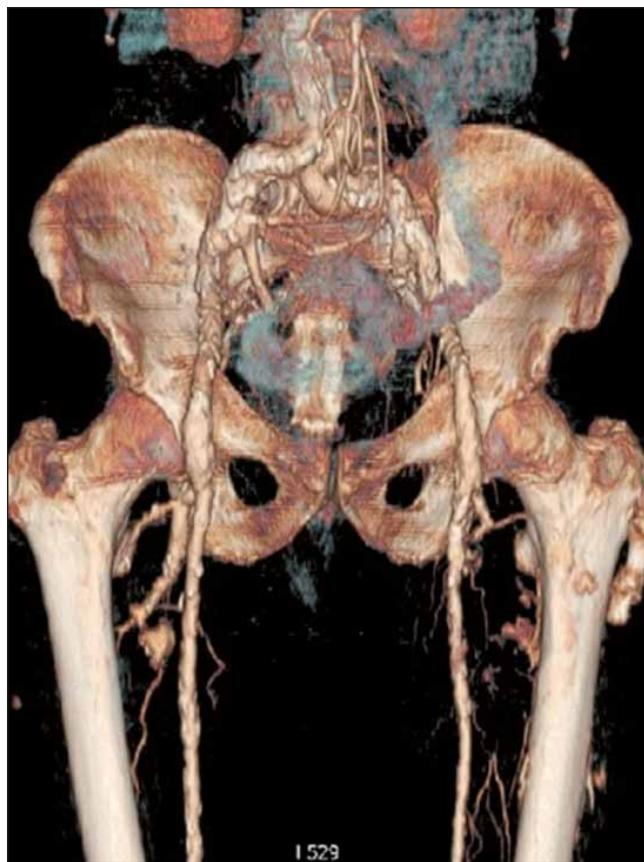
The control CT exam showed reduction in size of the hematoma with 25 mm and patent lumen of the left superficial femoral artery, which was no more compressed and dislocated.
